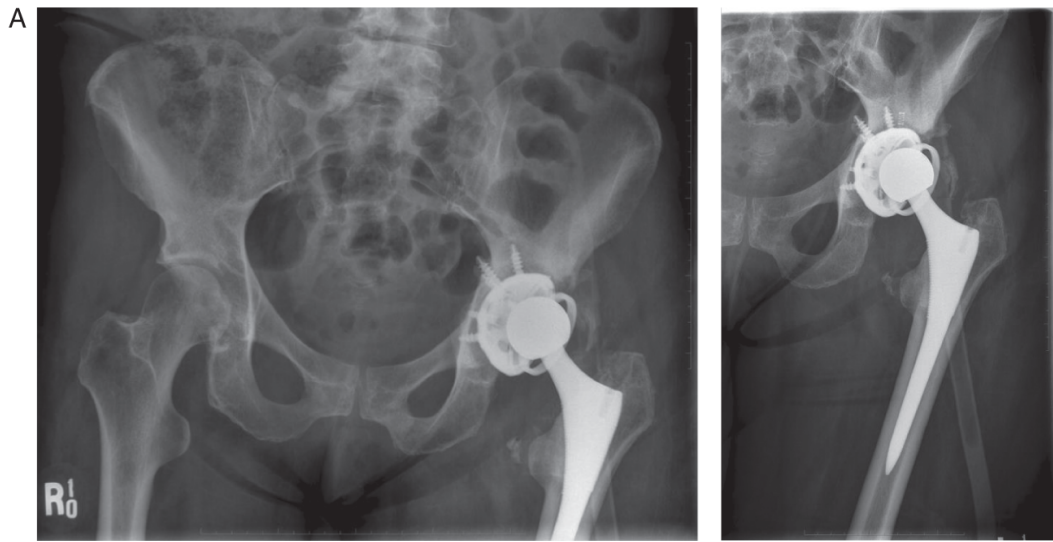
Radiographs: (A) preoperative; (B) first-stage; (c) second-stage.
